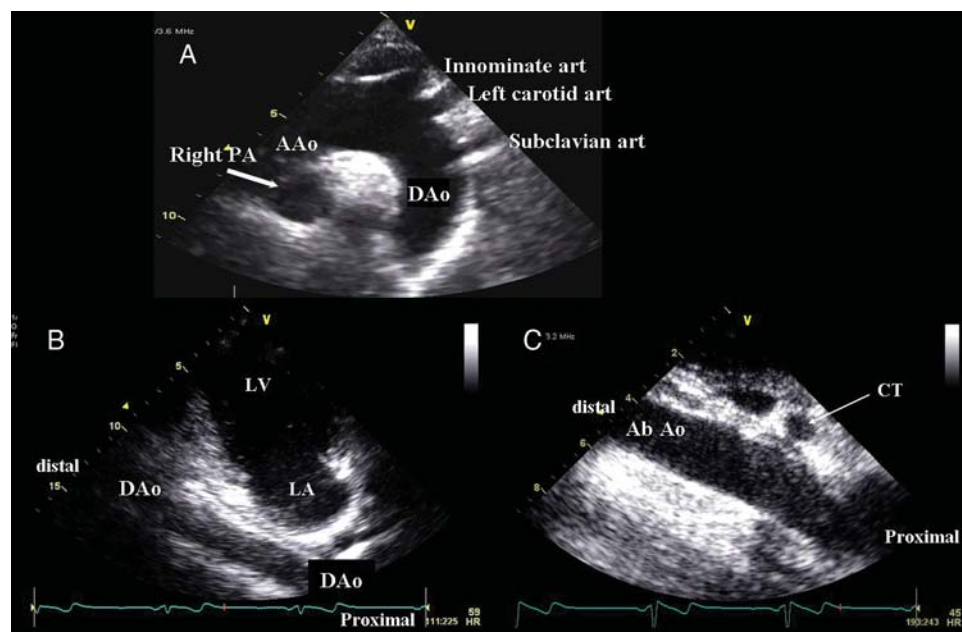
(A) Suprasternal view of aortic arch and supra-aortic great arteries. (B) Mid part of the descending thoracic aorta visualized by long-axis view from apical window. (C) Abdominal aorta visualized by subcostal view. In non-obese patients, it is not difficult to visualize distal abdominal aorta. art, artery; PA, pulmonary artery; AAO, ascending aorta; DAA, descending aorta; CT, coeliac trunk.
